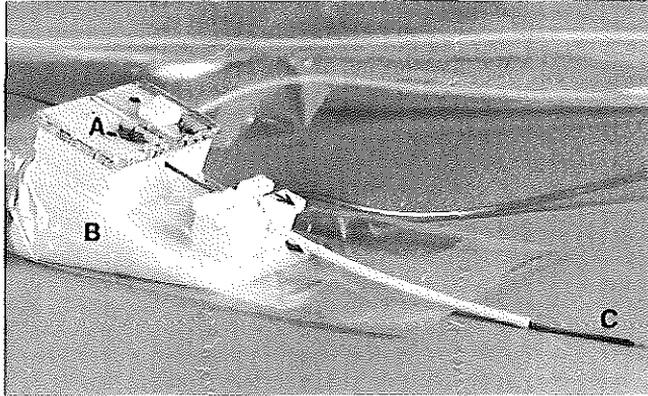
Displacement sensing device showing the sensing unit (A) and the registration part (B). The ultrasound catheter (C) is advanced via the sensing unit and the sheath.
